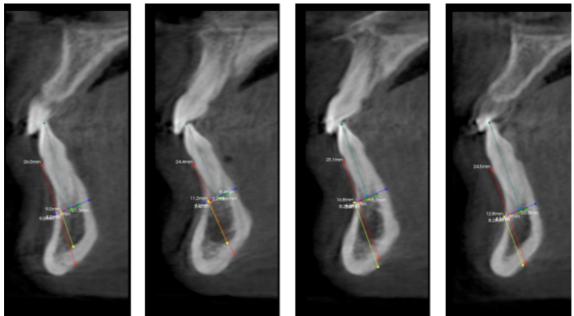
CBCT sagittal sections from patient 3. Incisors 32, 31, 41 and 42.
